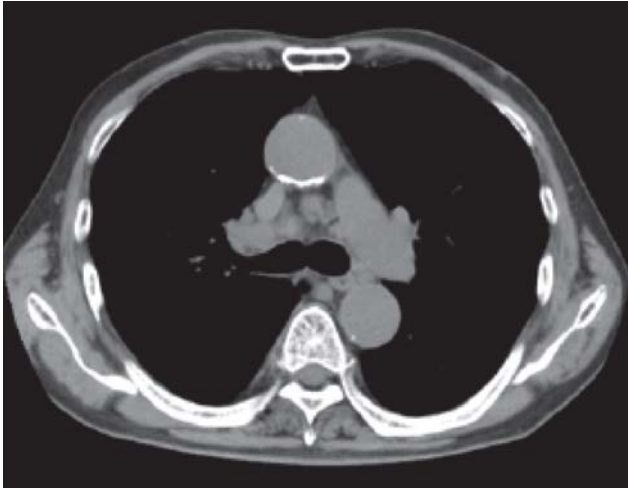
Computed tomography of the chest. A lymph node measuring 1cm×1cm can be seen at the mediastinum.
